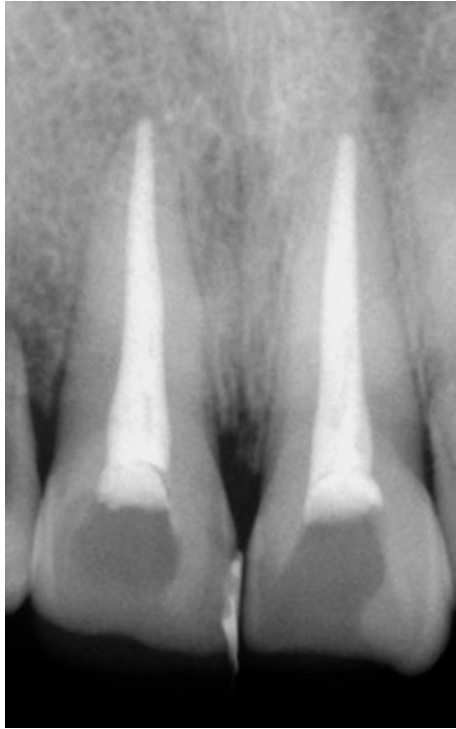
Radiographic view 3 years later.
